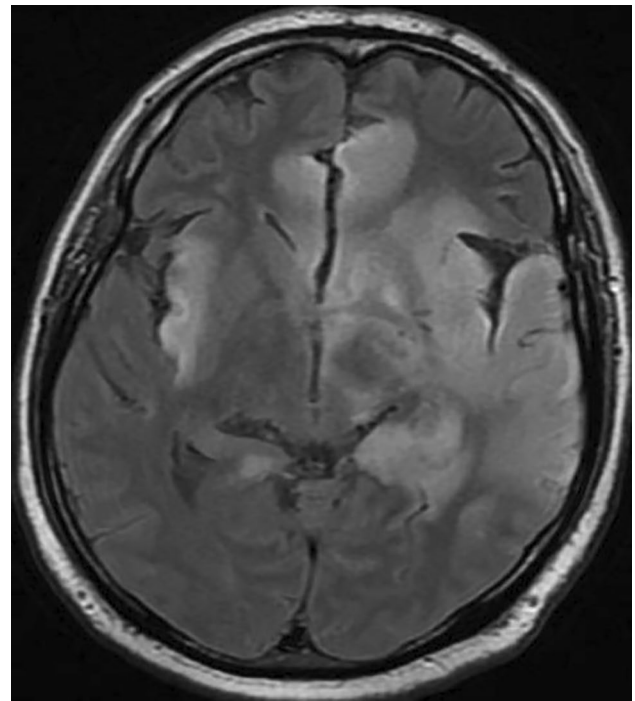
MR FLAIR image (done 5 days after admission) showing asymmetric hyperintensities involving both insula (left > right), bilateral medial temporal (left > right) and bilateral frontal (left > right) lobes along with mass effect
